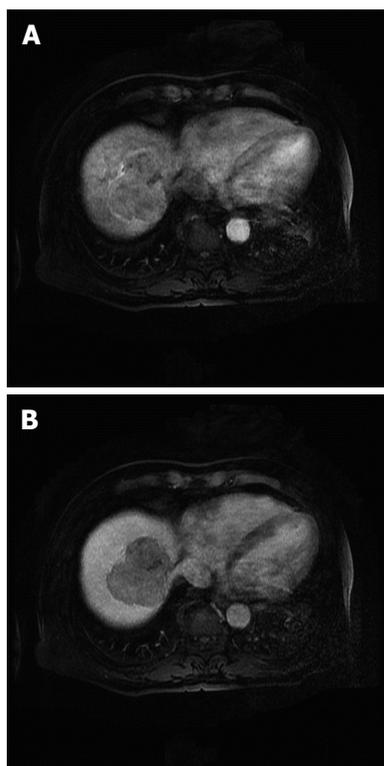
Dynamic liver magnetic resonance image showing a 6.8-cm solid mass in segments 8 and 7. A: Image obtained in the arterial phase, showing a lobulated enhancing mass; B: Image obtained in the portal phase, showing the mass evolving into a low-density mass.
